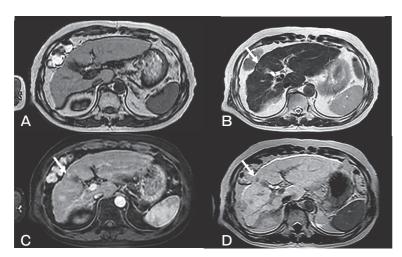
On abdominal magnetic resonance imaging (MRI), the smaller lesion near the gallbladder that was undetected by US and CT was also not observed on T1-weighted imaging (A), but was observed as a hyperintense mass on T2-weighted imaging (B). The same lesion was observed as a hyperintense mass in the artery phase (C) and as a hypointense mass in the hepatobiliary phase after the administration of Gd-EOB-DTPA.
